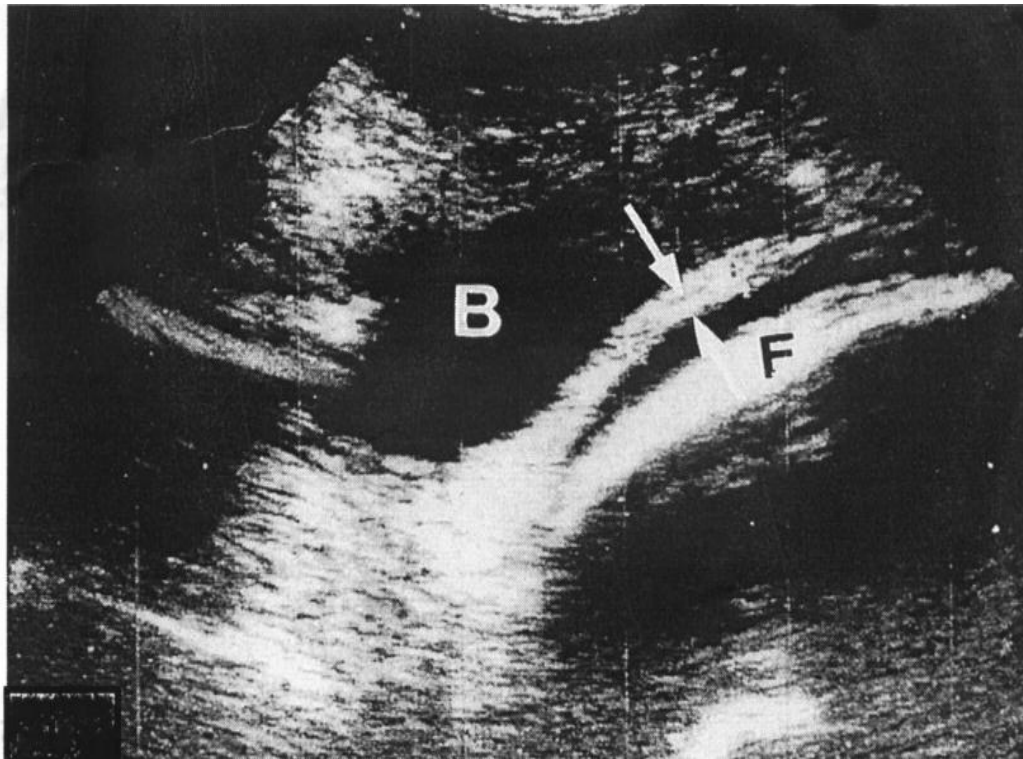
The myometrium shows thickness of less than 2 mm shown between the arrows in sonogram of a patient with poorly healed scar.
